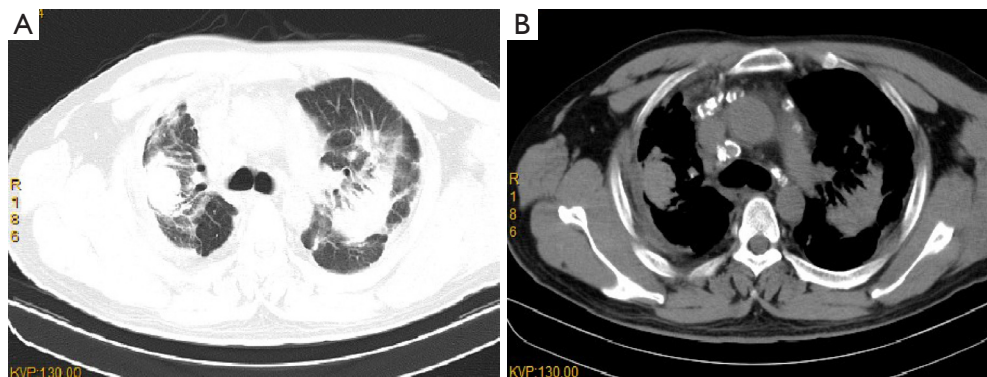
Chest computed tomography scan on March 10, 2023. (A) Progression of the fibrotic masses in the upper lobes of both lungs. (B) Multiple enlarged lymph nodes with calcification in the mediastinum and hilum of the lung, along with eggshell-like calcification of the lymph nodes.
